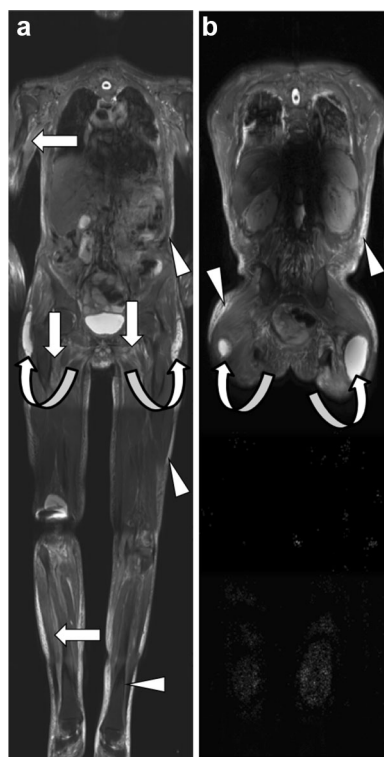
WBMRI images in a 46-year-old man suffering from a severe form of diffuse systemic sclerosis with myocardial, esophageal and lung involvement, presenting diffuse tendon friction rubs, tenosynovitis, and reduced range of motion in all joints. Coronal STIR MR images (a, b) show extensive musculoskeletal involvement with concurrent diffuse infiltration of subcutaneous tissue (arrowheads), muscles (arrows), and severe bilateral paratrochanteric bursitis (curved arrows). Note the presence of pleural and pulmonary involvement (b). Quantitative evaluation of these parameters is currently evaluated as biomarker of disease severity to evaluate response of experimental therapies (in this case oral glucocorticoids, mycophenolate mofetil and methotrexate)
